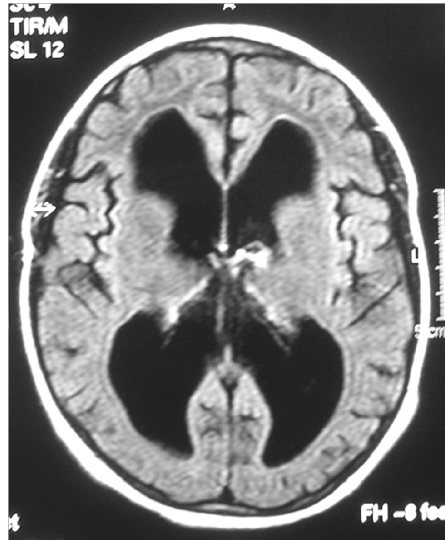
MRI, horizontal section of the brain showing hydrocephalus.
